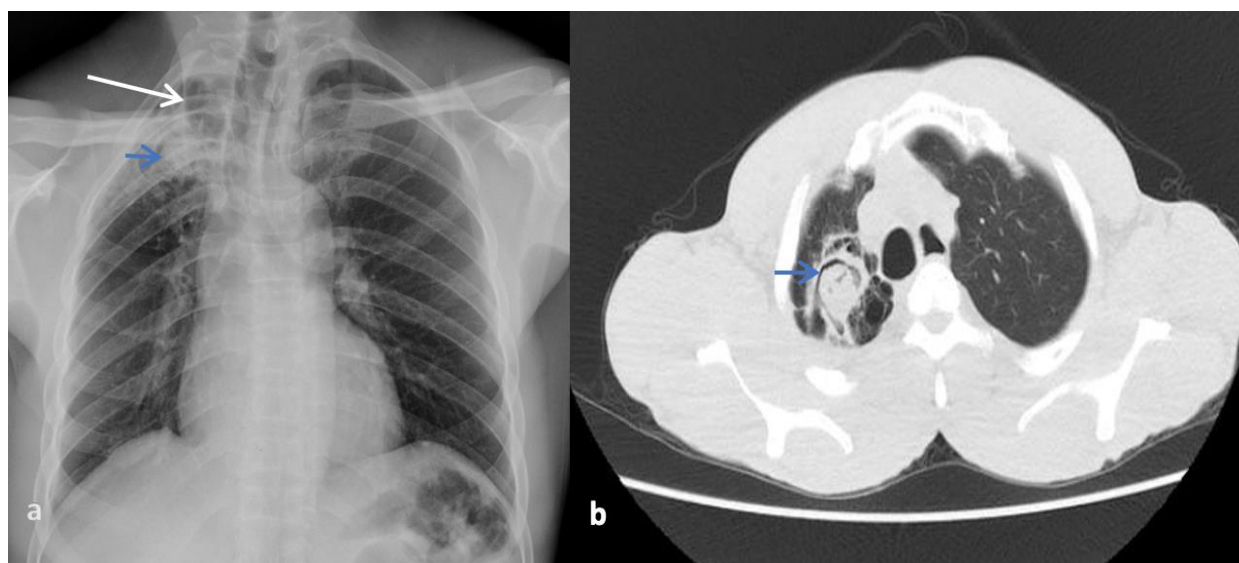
a. Plain frontal radiograph of a CPA patient, shows a right apical lung cavity (long white arrow) with a soft tissue density within it (short arrow), this is associated with pericavity fibrosis and volume loss evidenced by mediastinal shift to the right. b. Axial chest CT scan in lung window confirmed the presence of a right apical lung aspergilloma with an air crescent sign (short blue arrow) and surrounding fibrosis.
